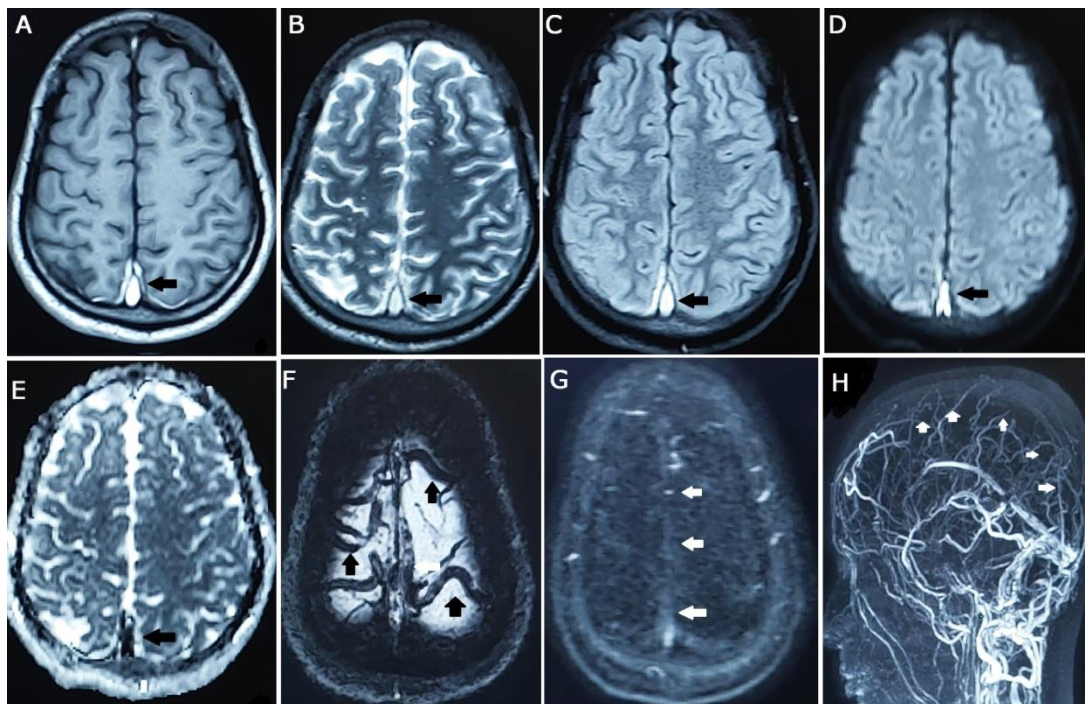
Late subacute complete CVT of superior sagittal sinus and cortical veins showing high signal on T1WI (A), T2WI (B), FLAIR (C), DWI (D), low signal on ADC (E), blooming artifact on SWI (F), non-visualization of flow on source image (G) and MIP image (H) on PC-MRV (arrows).
